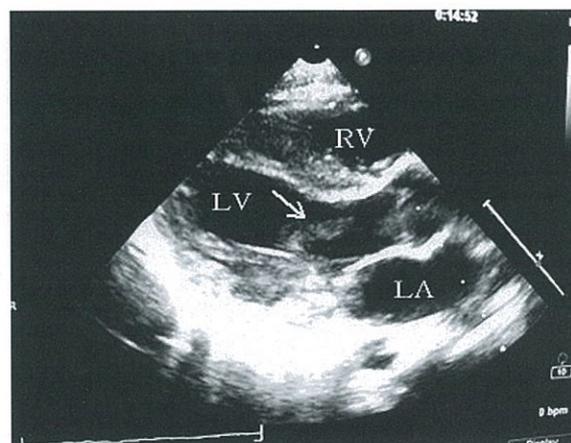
Large vegetations in the left ventricle (Echocardiography)
